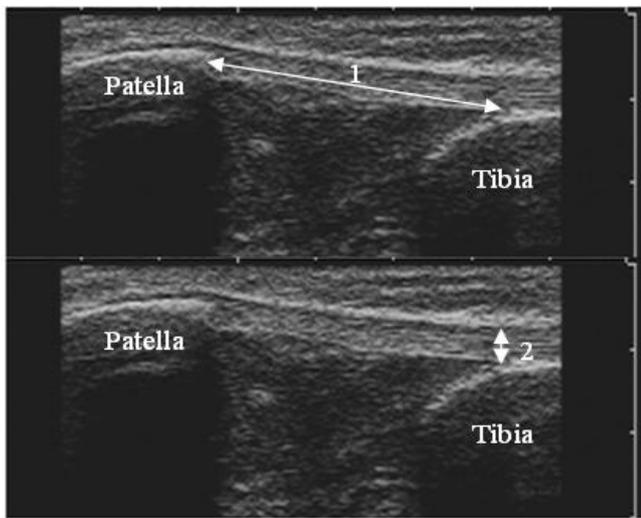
Ultrasound images of patellar tendon, located between the patella and tibia bone region. Arrow 1 represents the length and arrow 2, the thickness of the patellar tendon.
